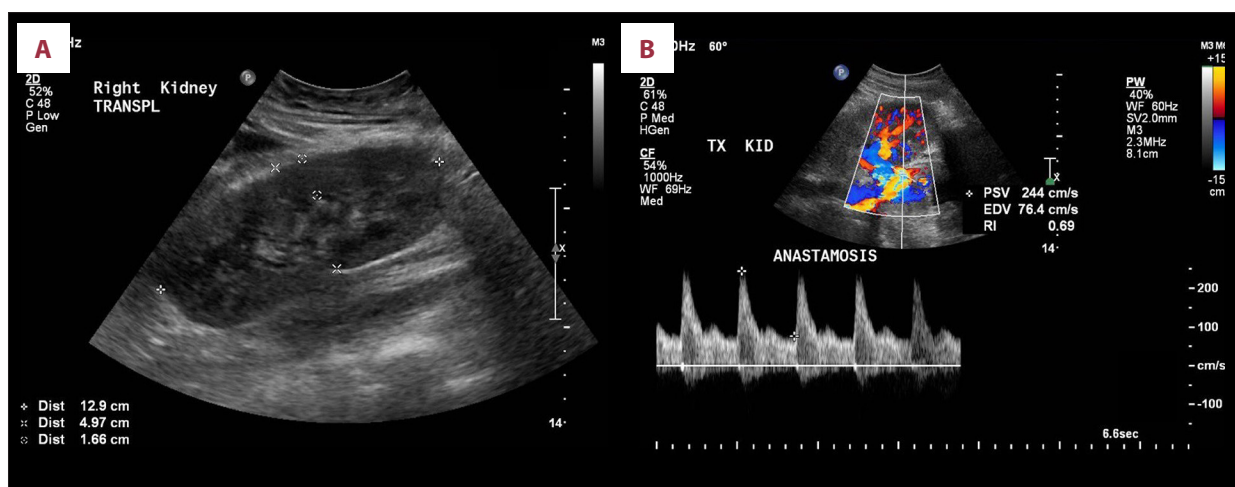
Renal ultrasound showing: (A) Increased size and echogenicity of transplanted kidney. (B) Increase in resistive index of the main renal artery.
